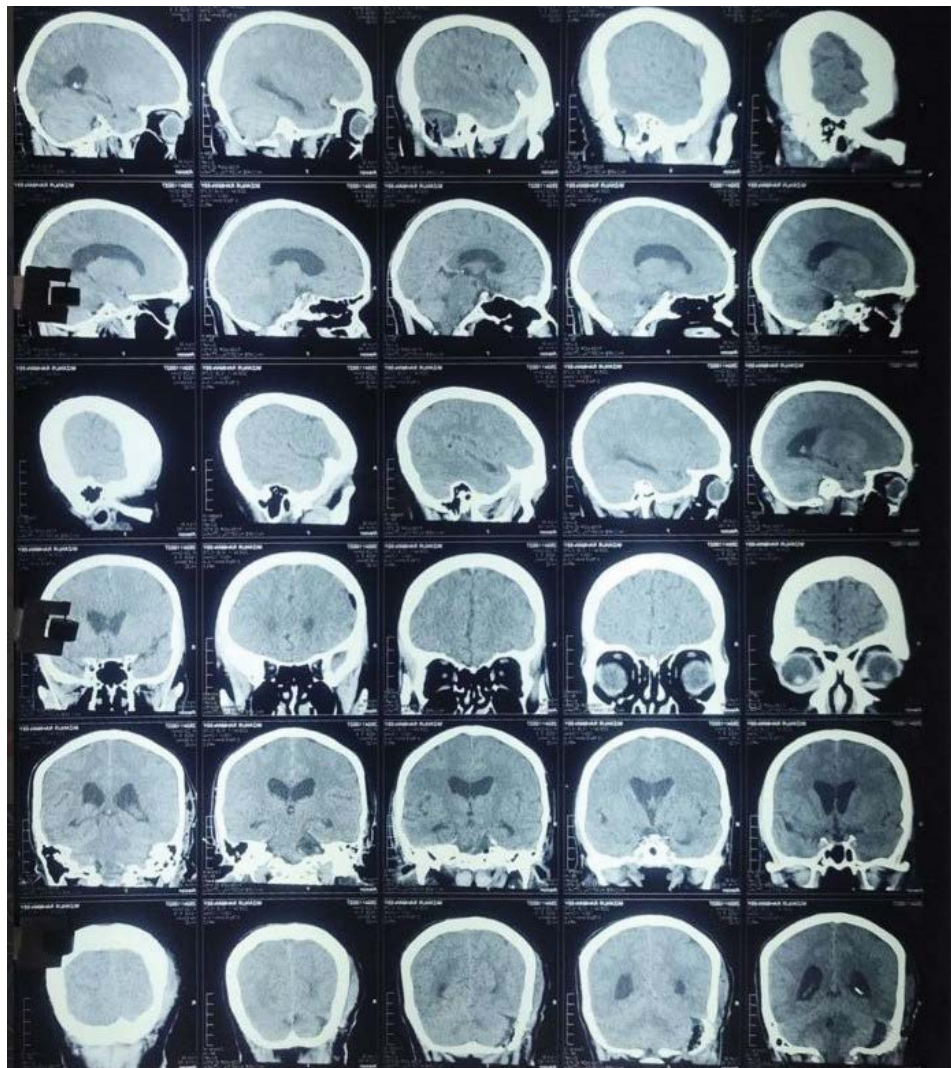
Image showing MRI of the brain suggesting right CPA acoustic neuroma having tumor necrosis extending into the internal acoustic meatus with gross compression over the brain stem and 4th ventricle resulting mild obstructive supratentorial hydrocephalus.
